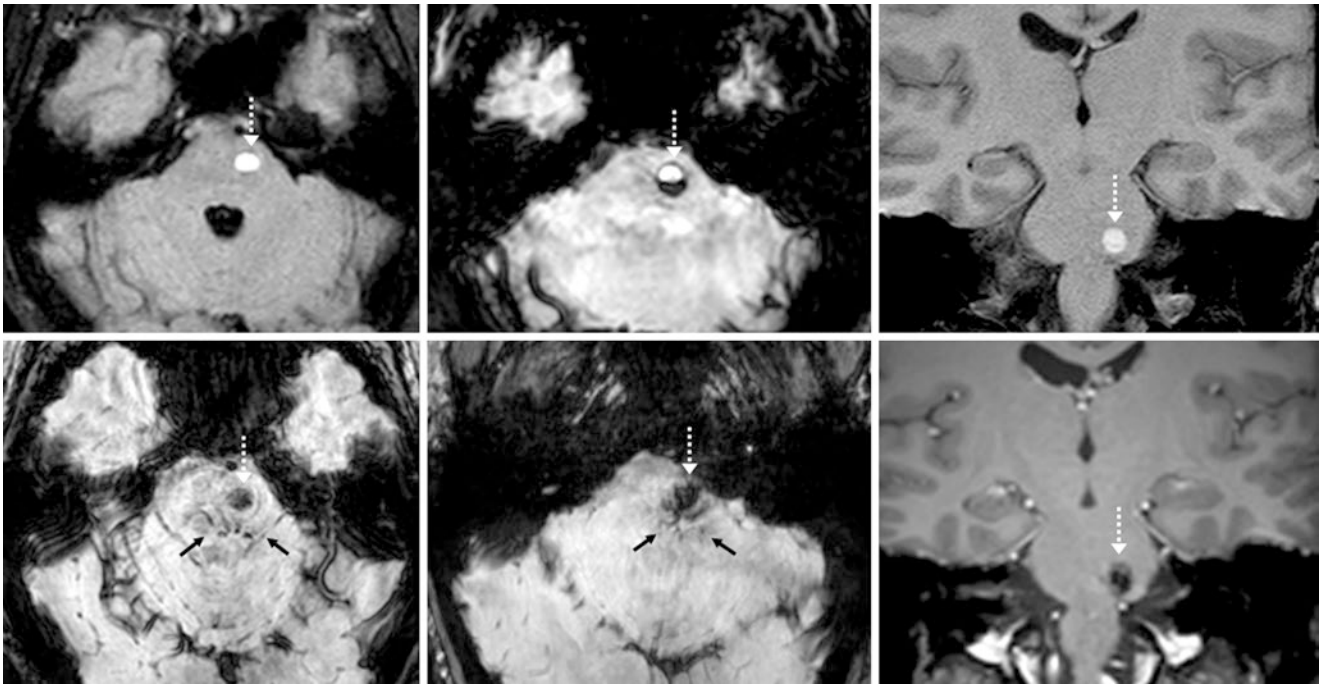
Comparison case of a cavernoma with DVA. A 30 year old had focal hemorrhage of the left hemipons on a 1.5T MRI (*dotted arrows*) with FLAIR (*top left*), SWI (*top middle*), and coronal T1WI (*top right*). At 6 months, SWI 2-mm and 4-mm reformats (*bottom left*
